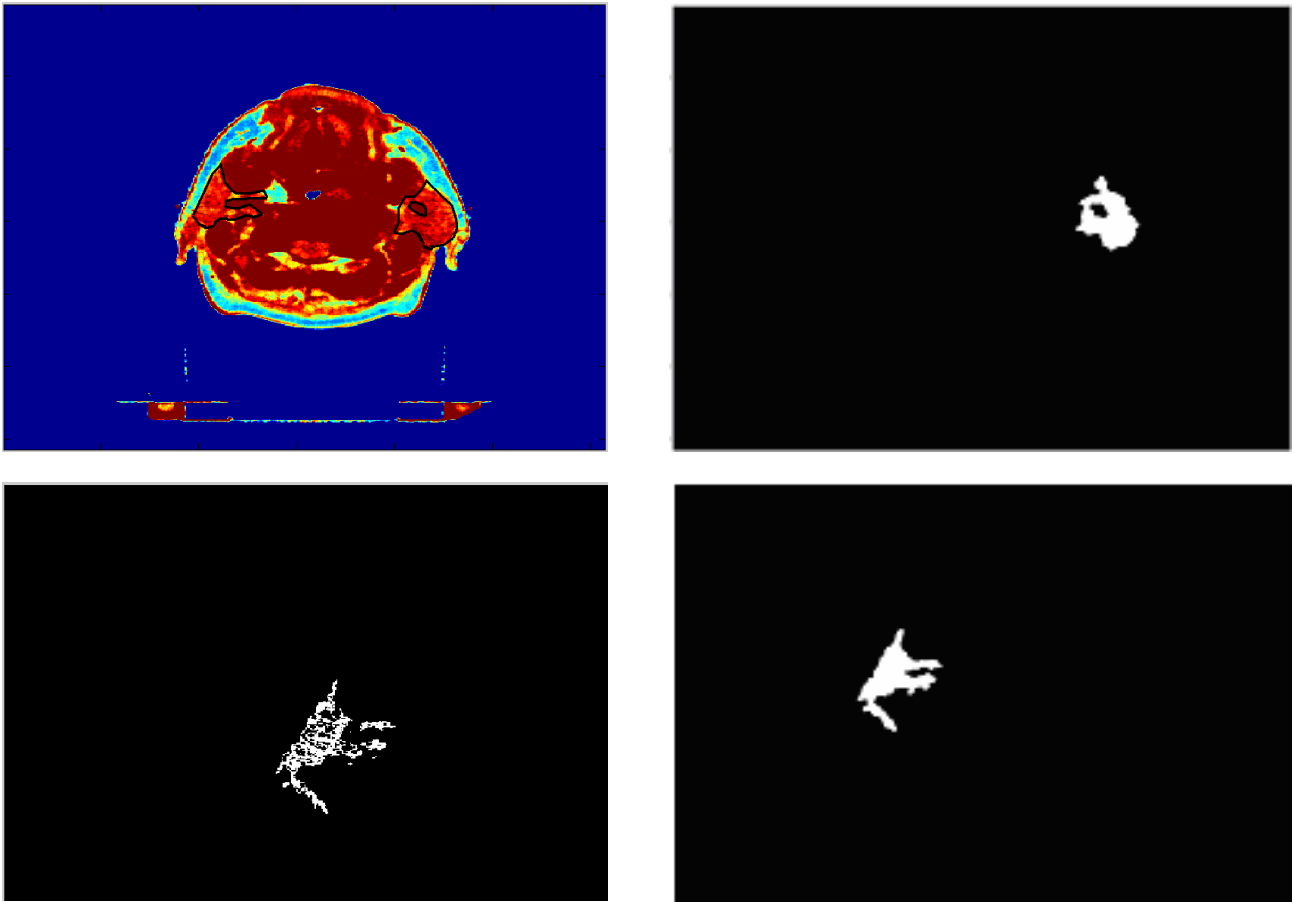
On the top-left the CT-Scan image and the parotid glands manually segmented in black. On bottom left we have the direct result of the left parotid gland segmentation. On the right column we have the results after post-processing of the right parotid gland (top-right) and left parotid gland (bottom-right)
